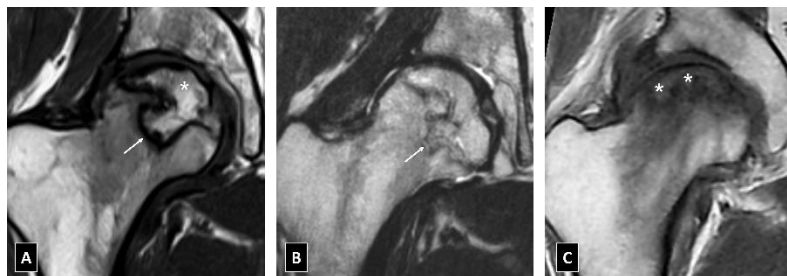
(A) Coronal T1-weighted and (B) coronal T2-weighted MR images show the necrotic lesion with fat-like signal intensity (asterisk in A), surrounded by a low T1 rim (arrow in A). On spin-echo T2-weighted images, the double line sign is frequently seen (arrow in B). (C) Coronal T1-weighted MRI shows the non-fatty signal intensity of the necrotic lesion (asterisks).
